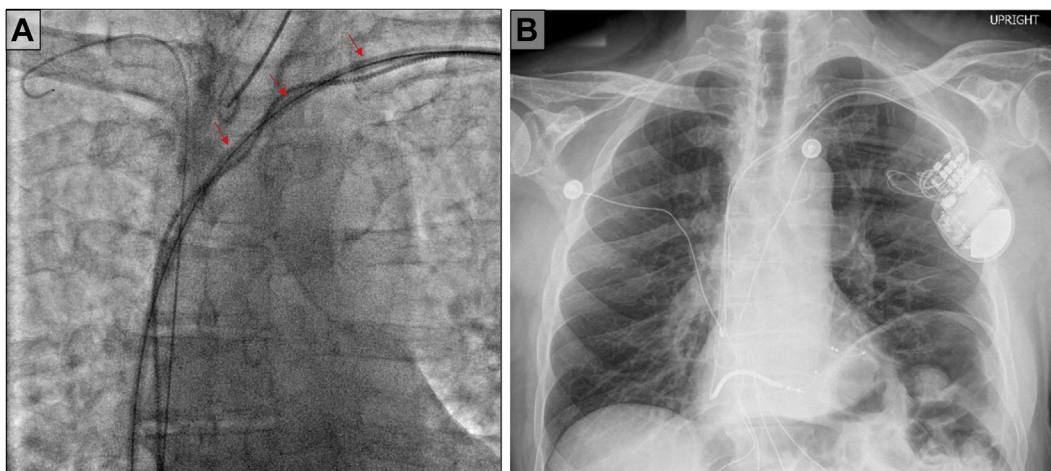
A: Long sheath (*red arrows*) advanced over the Glidewire Advantage (Terumo, Tokyo, Japan) beyond the site of stenosis. B: Postprocedure chest radiograph demonstrating biventricular implantable cardioverter-defibrillator implant.
